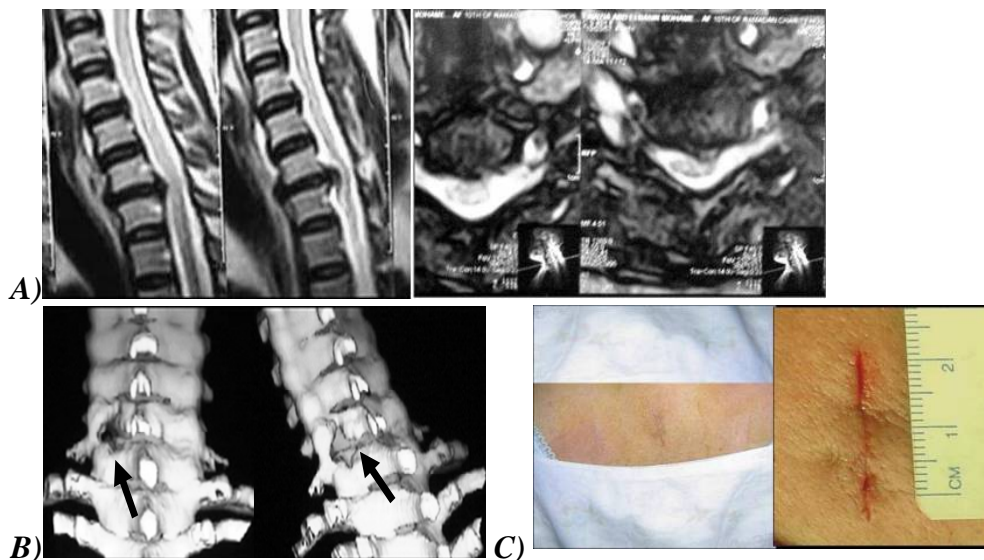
A) preoperative MRI shows lateral disc C6-7. B) 3D-CT scan shows the site of foraminotomy and intact facets and joints. C) A small vertical skin incision (2cm)
